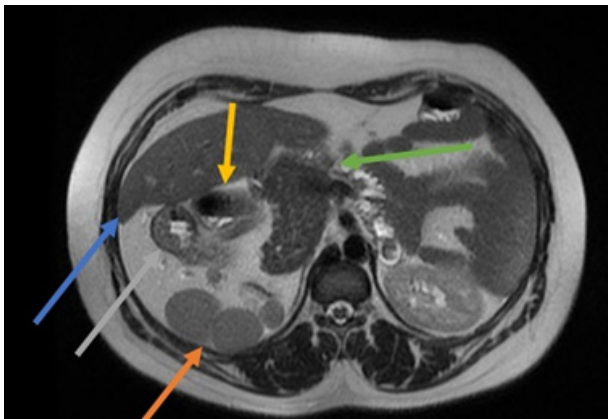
MRI in axial section in T2 sequence showing usual hepatic parenchyma in the right abdomen (blue arrow), ectopic splenic tissue with splenosis (orange arrow), gastric curvature in the right abdomen (gray arrow), duodenum (yellow arrow), and dorsal pancreas agenesis (green arrow).
